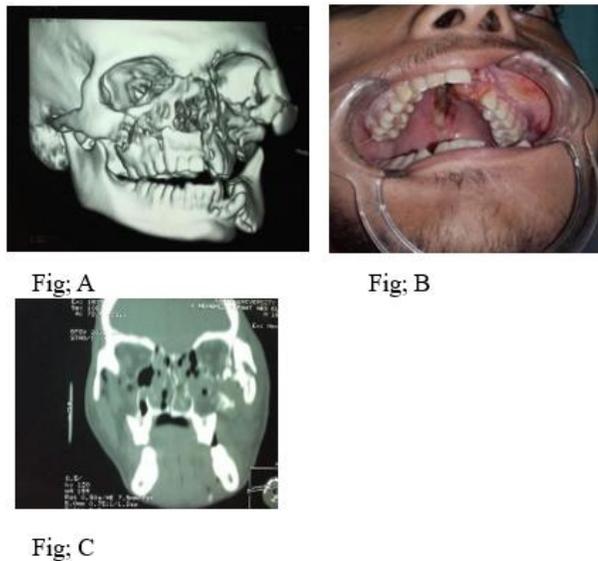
Preoperative View; (A) preoperative 3D CT; (B) Preoperative occlusion; (C) coronal view.
